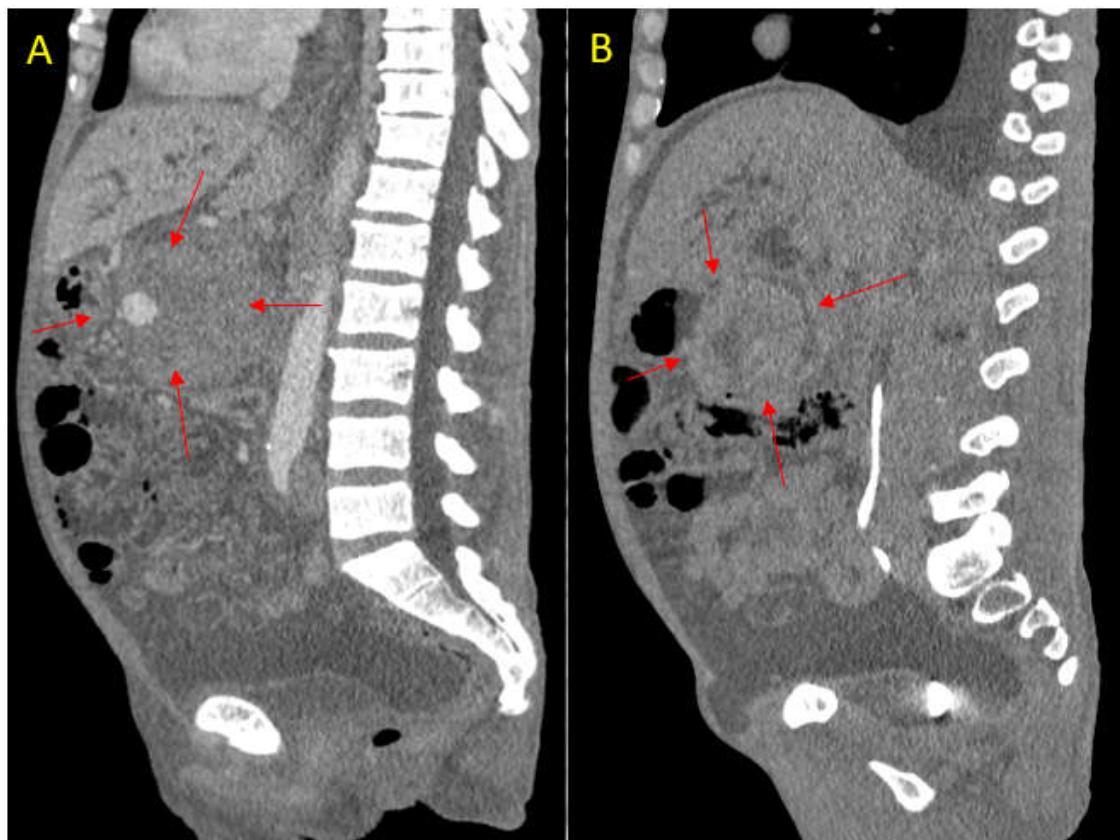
Axial section computed tomography, before and after contrast agent administration, in the arterial phase, showing heterogeneous expansive lesion, with significant vascular enhancement in its true luminal portion, in close contact with the adjacent vascular arterial segment. The lesion is located in the epigastrium / hypogastrium on the right, in close contact with the pancreatic head and bile duct structures
